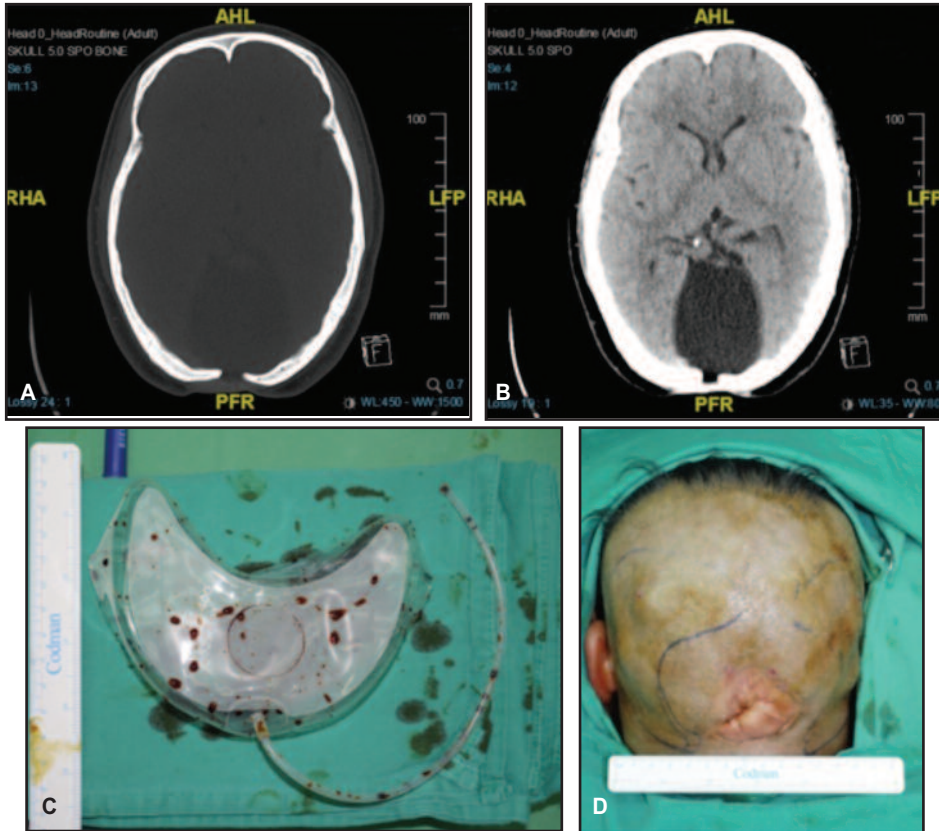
CT scan images of bone (A) and soft tissue (B) windows. One of the crescentic tissue expander with external port, soaked in povidone iodine (C). Posterior view of occipital scalp defect with marking prior to tissue expanders insertion (D).
